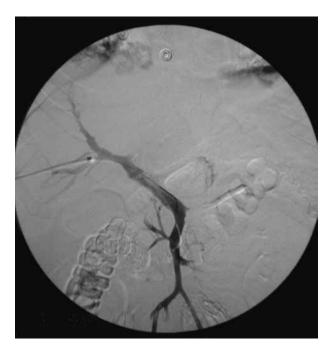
Delayed angiogram after 19 hours of treatment with tissue plasminogen activator and therapeutic ultrasound show all the veins close to the EKOS catheter including the right portal vein, main portal vein, and superior mesenteric vein to be clot free with good flow.
